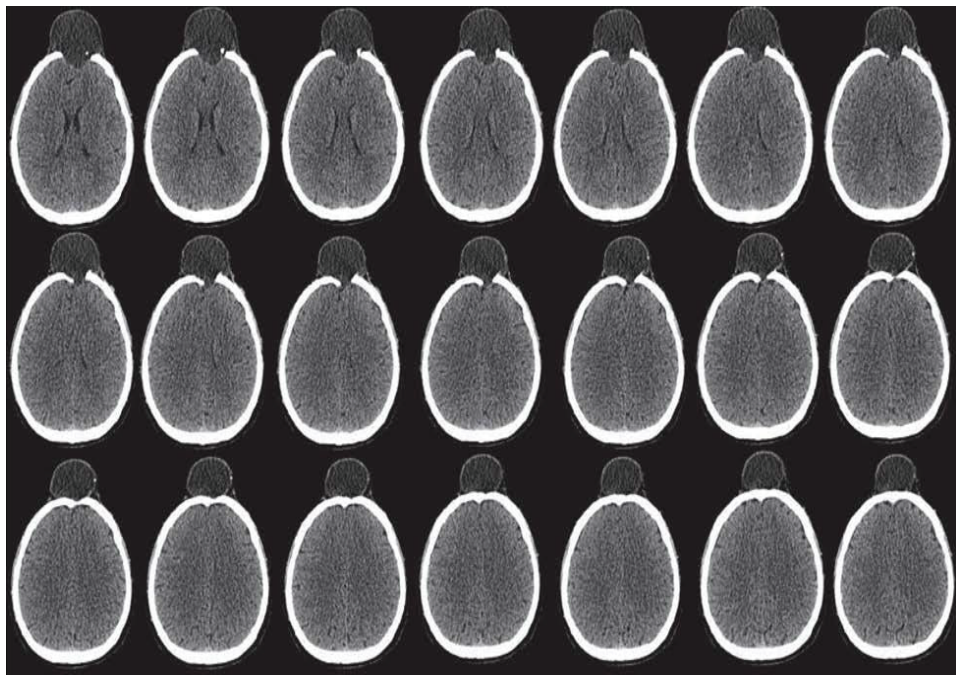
CT scan images of patient with frontal bone fracture
